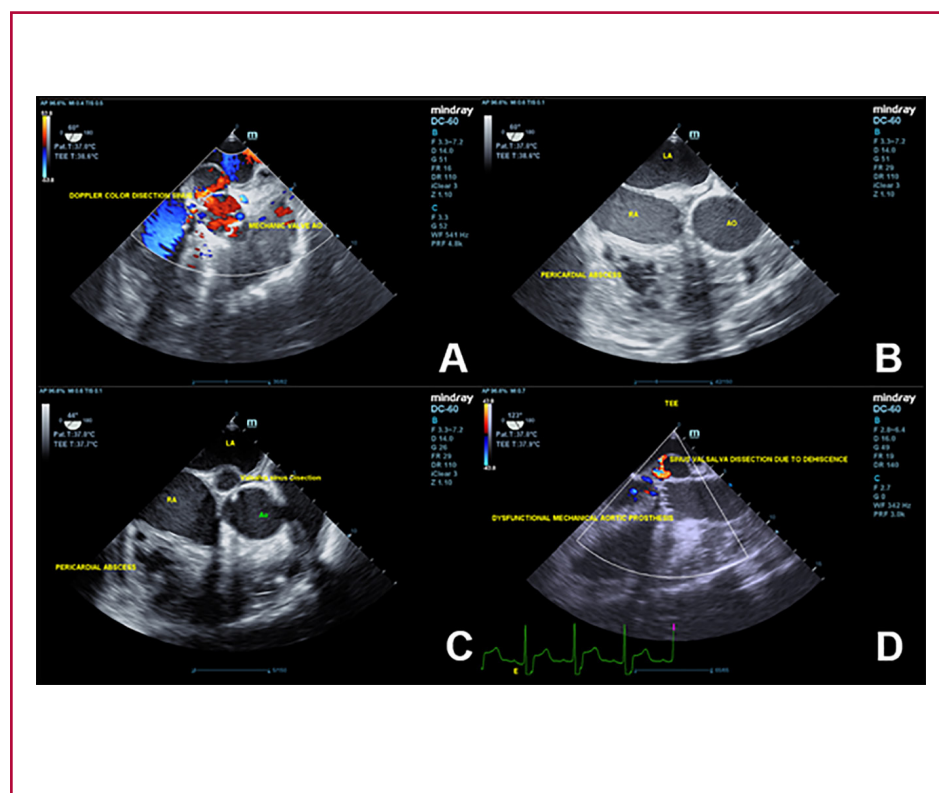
A. Transesophageal echocardiogram showing a mechanical aortic prosthesis with dissection of the sinus of Valsalva. Note the color Doppler flow of the dissection jet. B. Transesophageal echocardiogram with septated pericardial space image compatible with abscess. LA: Left Atrium, RA: Right Atrium, AO: Aorta. C. Transesophageal echocardiogram in short axis view for large vessels where the dissected sinus of Valsalva is observed; inferior to the right atrium, a fibrinoid image is observed in the pericardial space. LA: Left Atrium, RA: Right Atrium, AO: Aorta. D. Transesophageal echocardiogram showing mechanical aortic prosthesis with dehiscence and aneurysm of the sinus of Valsalva; below the aortic valve, there is rupture of the interventricular septum, with color Doppler flow from the left ventricle to the right ventricle
